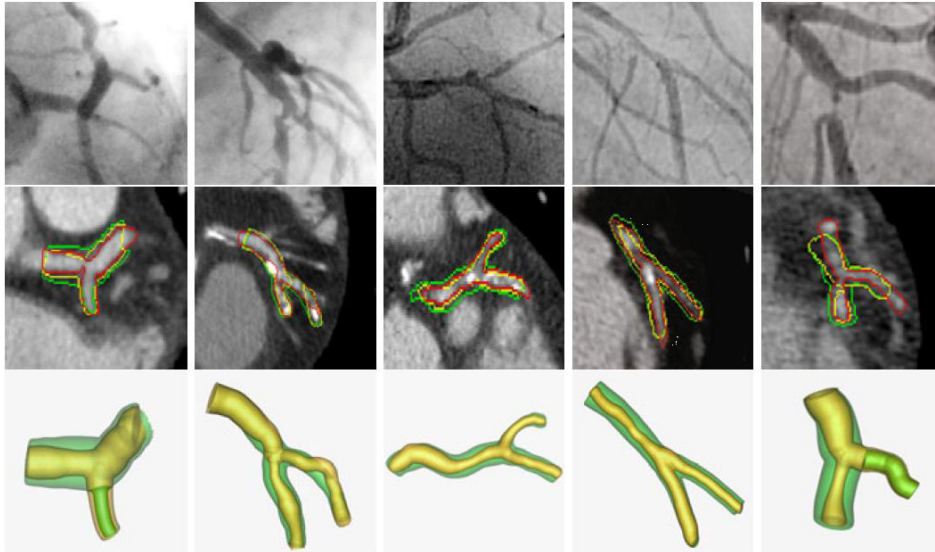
Top row: CCA images of the five coronary bifurcation investigated. Middle row: corresponding bifurcation plane from CTA images with manual segmentation (red), pre- (yellow) and post-operative (green) outlines overlaid. Bottom row: 3D geometrical models of the bifurcations, with inner lumen referred to the pre- (yellow) and the post-operative (green) models. Image copied with permission from Cardenes et al. [25].*
